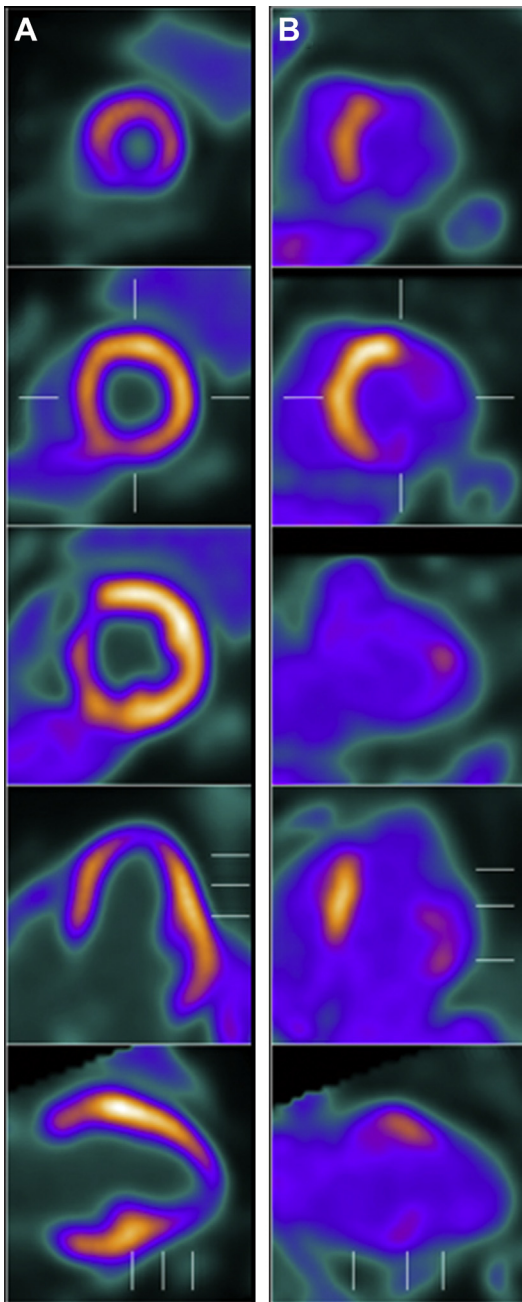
^{18}F -FDG and N-13 ammonia PET/CT for CS. A myocardial perfusion defect is present in the septum on N-13 ammonia imaging (A) with corresponding ^{18}F -FDG uptake in the same territory (B) consistent with active CS.
